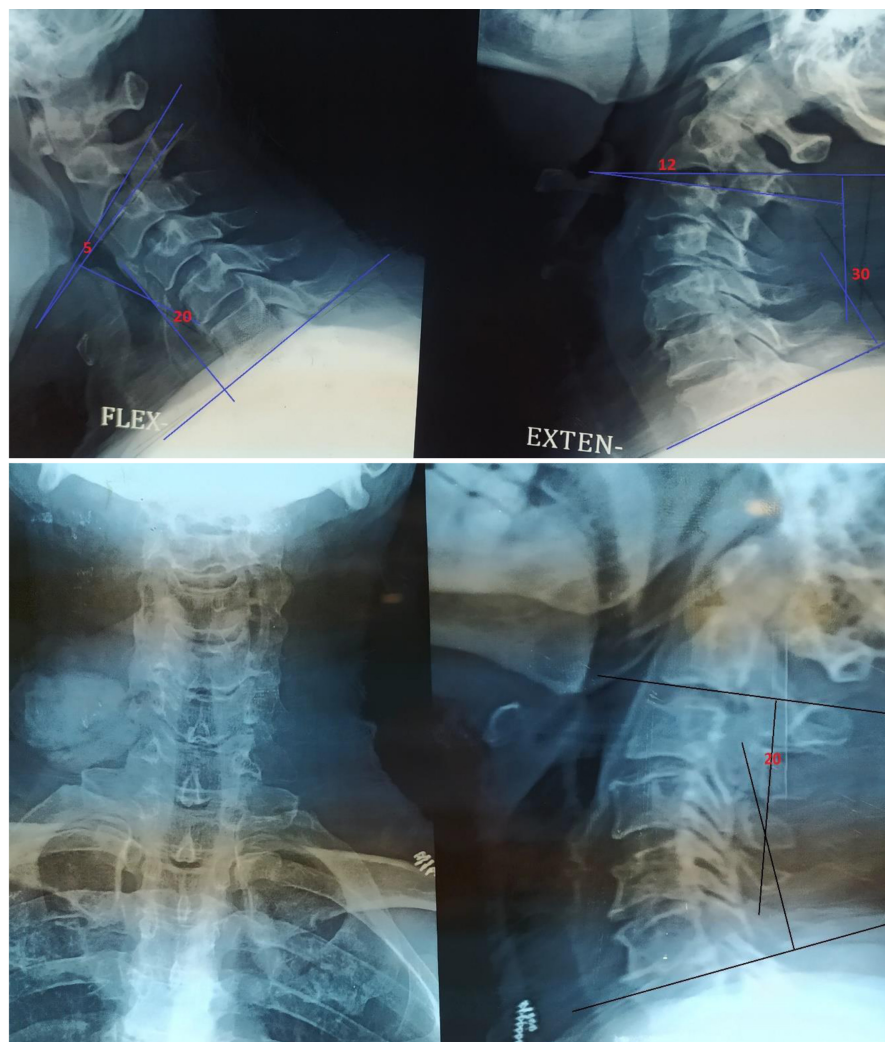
Preoperative cervical spine X-ray (AP, lateral, extension, flexion) of a 45 years old female patient presented to us complaining of gradual onset and progressive course of right brachialgia and right U.L weakness for 3 months. It showed that Global lordosis was 20 and global ROM was 50 (30 for ROM in extension and 20 for ROM in flexion). Cranial adjacent ROM was 17 (12 for extension and 5 for flexion).
